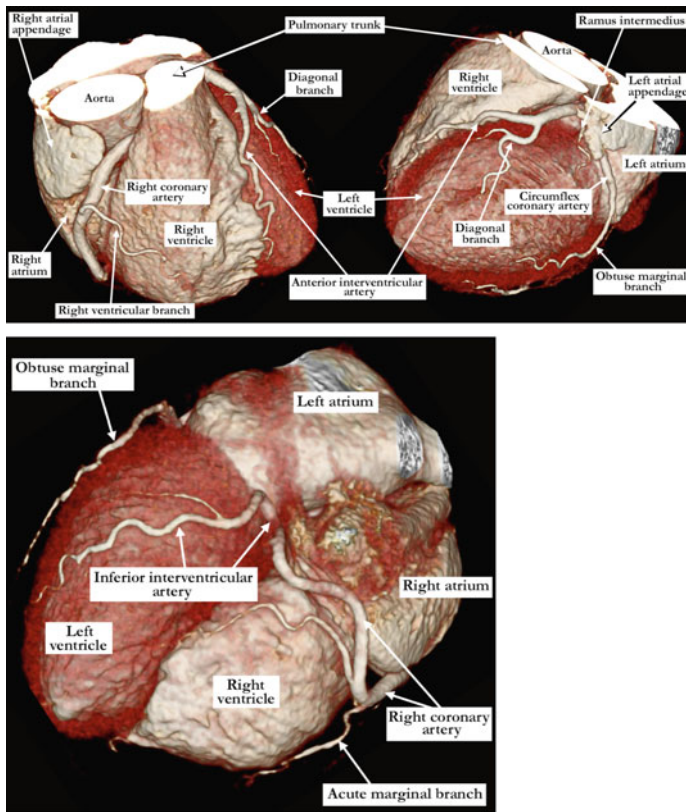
Cardiac CT Angiography performed with AIDR 3D (Canon medical system) showing the coronary arteries from an attitudinally appropriate approach
